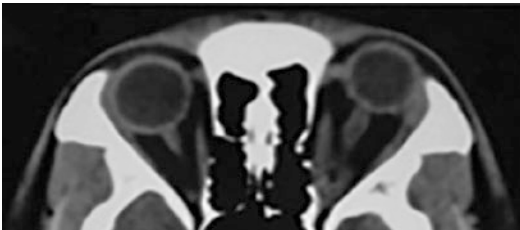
CT scan of orbit shows bulky optic nerve
